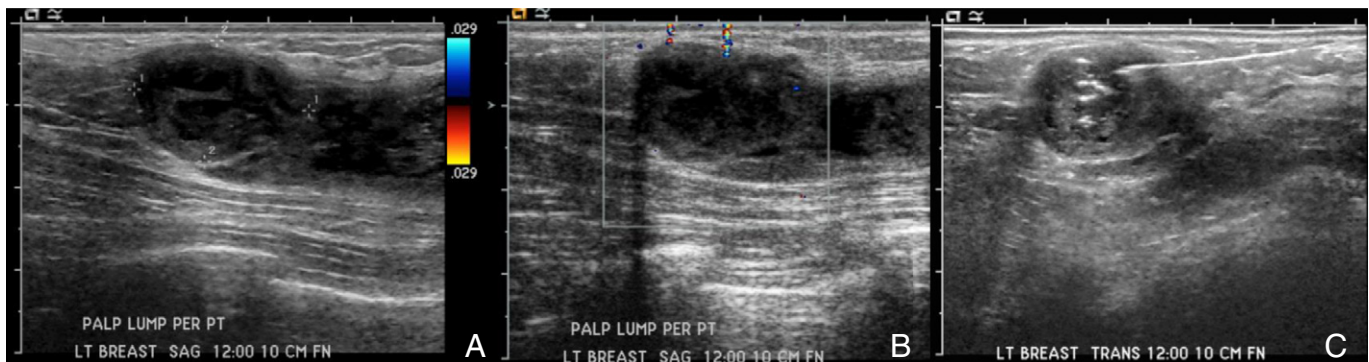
Case #1: Left breast ultrasound images. (A) Left breast sagittal grayscale ultrasound demonstrating a complex cystic mass measuring 2.1×1.5×2.0 cm. (B) Left breast sagittal color Doppler ultrasound shows that the mass is avascular. (C) Left breast transverse gray-scale ultrasound during fine needle aspiration.
